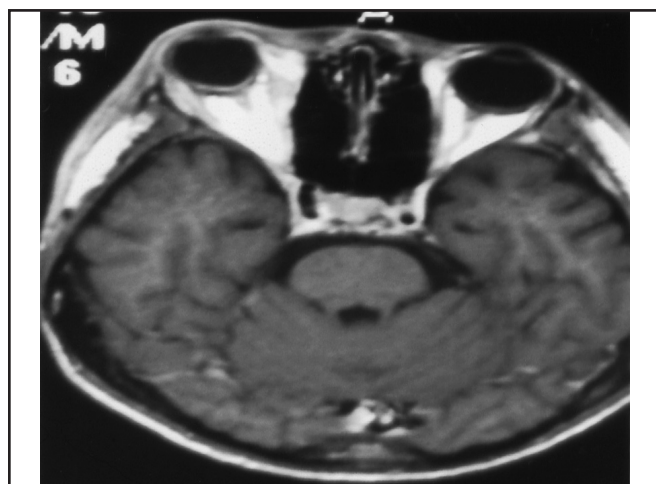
MRI of the orbit, axial view reveals proptosis of the right eye
